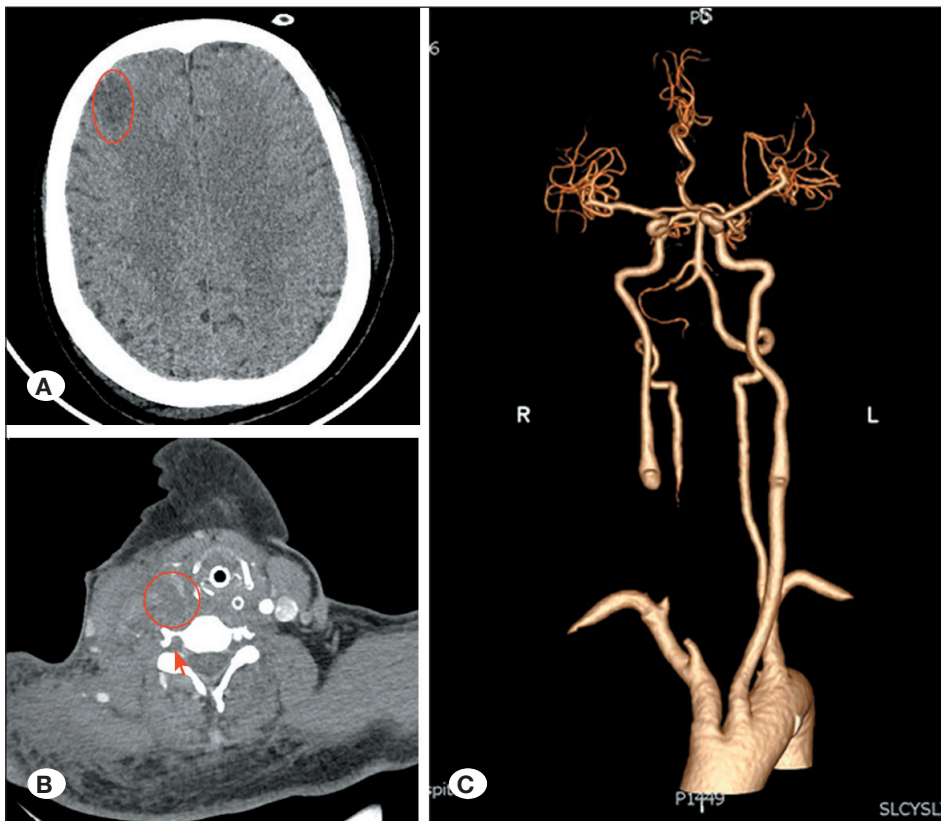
Postoperative images of case 1. A) Non-contrast cranial CT showing a small ischemic infarction in the ipsilateral frontal cerebral lobe. B) Postoperative occlusion of the injured CCA and VA segments. The red circle indicates the occluded right CCA segment. Red arrow indicates an occluded segment of the right VA. C) CTA showing the relative occluded lengths of the right CCA and VA. CCA: Common carotid artery; CT: Computed tomography; CTA: computed tomography angiography; VA: vertebral artery.
